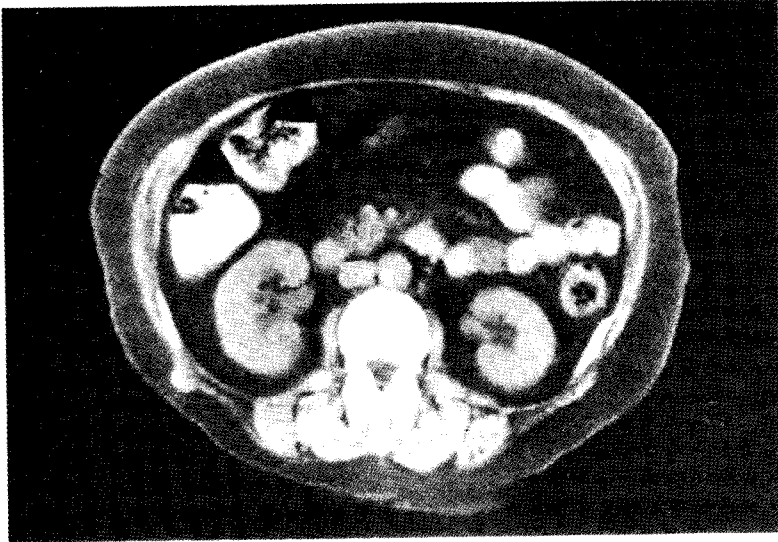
CT scan taken through the kidneys
